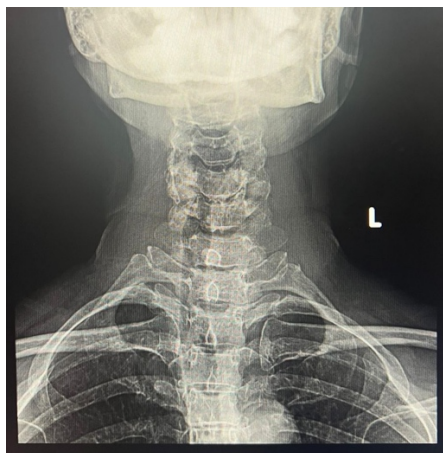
Neck X-ray showing a large bilateral neck mass, more prominent on the left, which deviates the trachea to the right without causing significant airway constriction.
